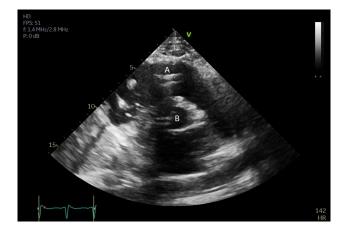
A parasternal short axis view at the level of the aortic valve on a transthoracic echocardiogram. The Impella RP devices is seen in the RVOT. (A) Impella RP in the RVOT. (B) Aortic valve with a left sided Impella seen traversing it.
